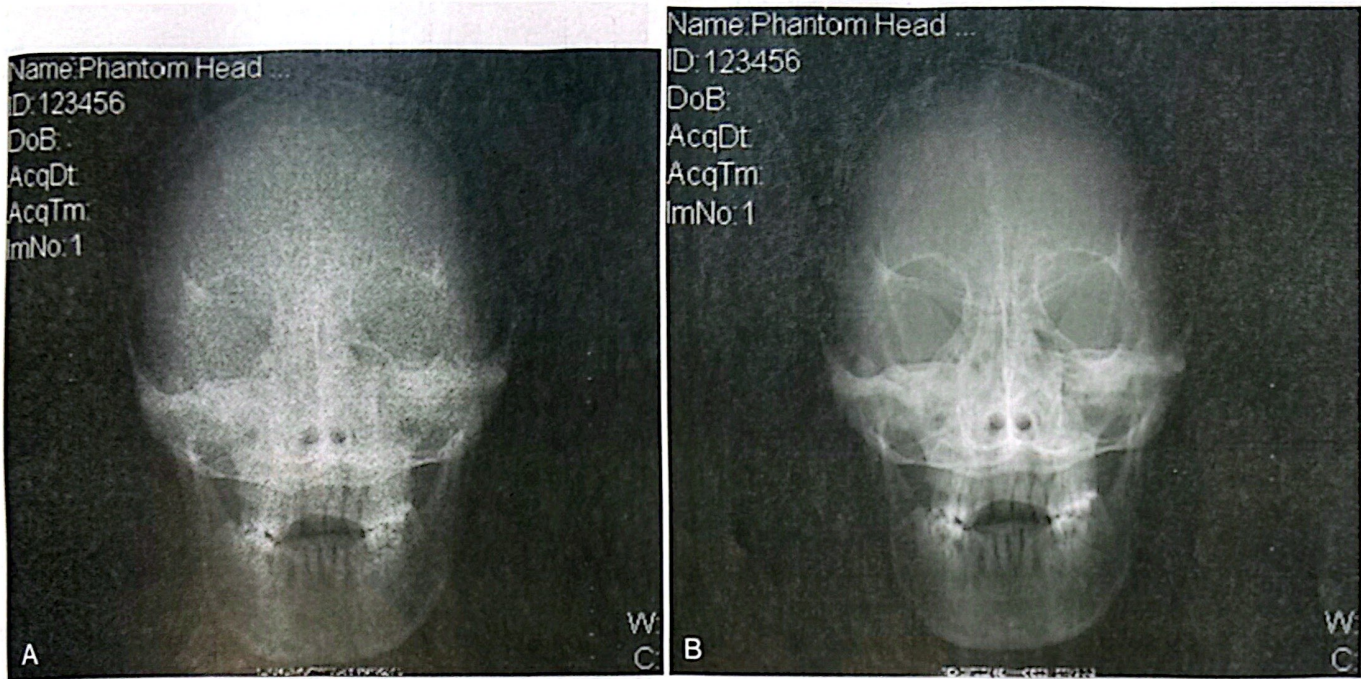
Computed radiography images showing the effect of underpenetration. (A) Anteroposterior projection of the skull underpenetrated at 58 kVp. The computer was unable to create a diagnostic image because not enough x-rays reached the detector. Quantum mottle, or noise, is evident. (B) Same projection correctly penetrated at 85 kVp. Use of the correct kilovoltage is critical when using digital systems.
